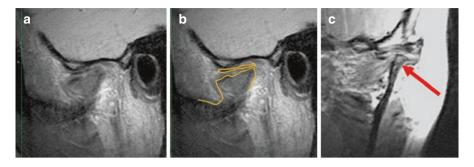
(a) MRI of TMJ with juvenile idiopathic arthritis (JIA). The sagittal view demonstrates that the disc is commonly in position but surrounded by a reactive pannus (gray tissue around the degenerated disc and condyle) that destroys the disc, condyle, and articular eminence. The remaining condyle has a "mushroom" appearance. (b) The condyle and disc are outlined in orange. (c) Coronal view showing the extreme narrowness of the residual condyle
